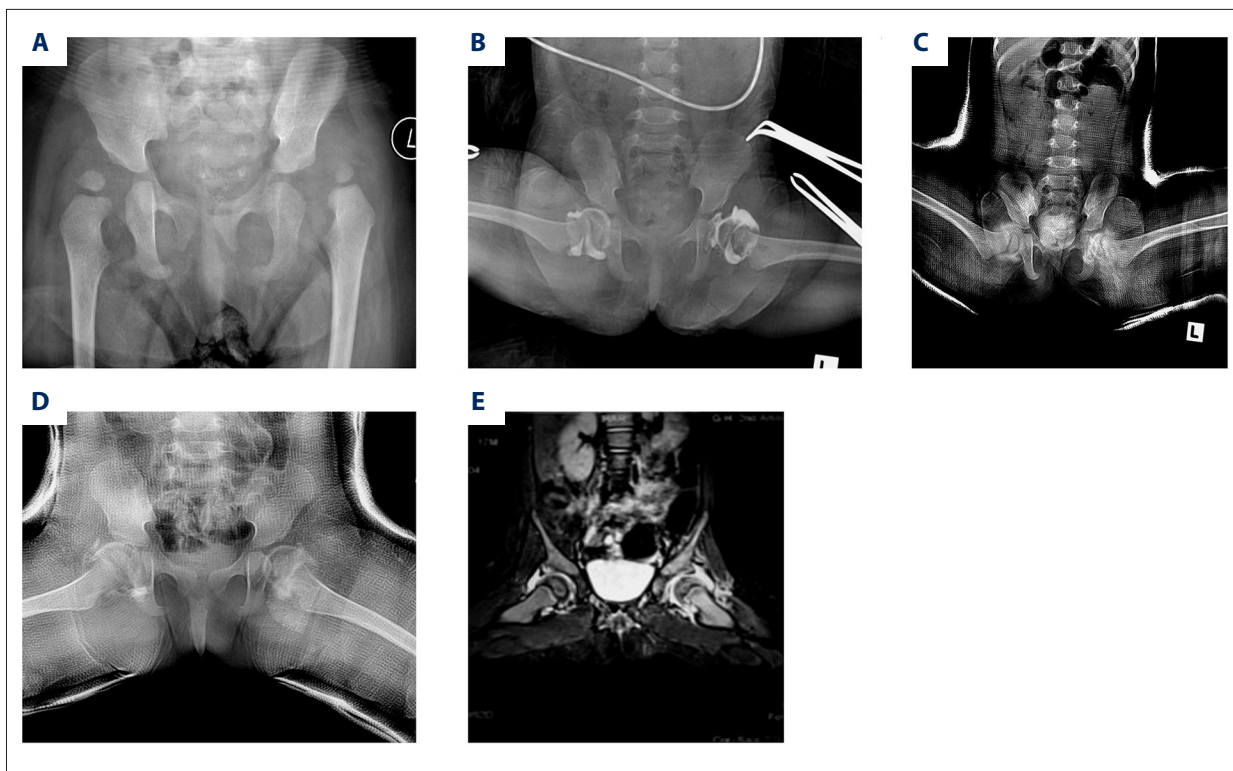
A female infant aged 14 months with developmental dislocation of the hip (DDH). (A) Bilateral dislocation of the hip before the operation. (B) Labrum varus following the removal of the adductor muscle and iliopsoas muscle. (C) External fixation using the frog-leg plaster cast with fixed flexion and abduction of the hips following the arthroscopic debridement. (D, E) Second-stage frog-leg cast external fixation at six weeks following the arthroscopic reduction on plain X-ray and magnetic resonance imaging (MRI).
